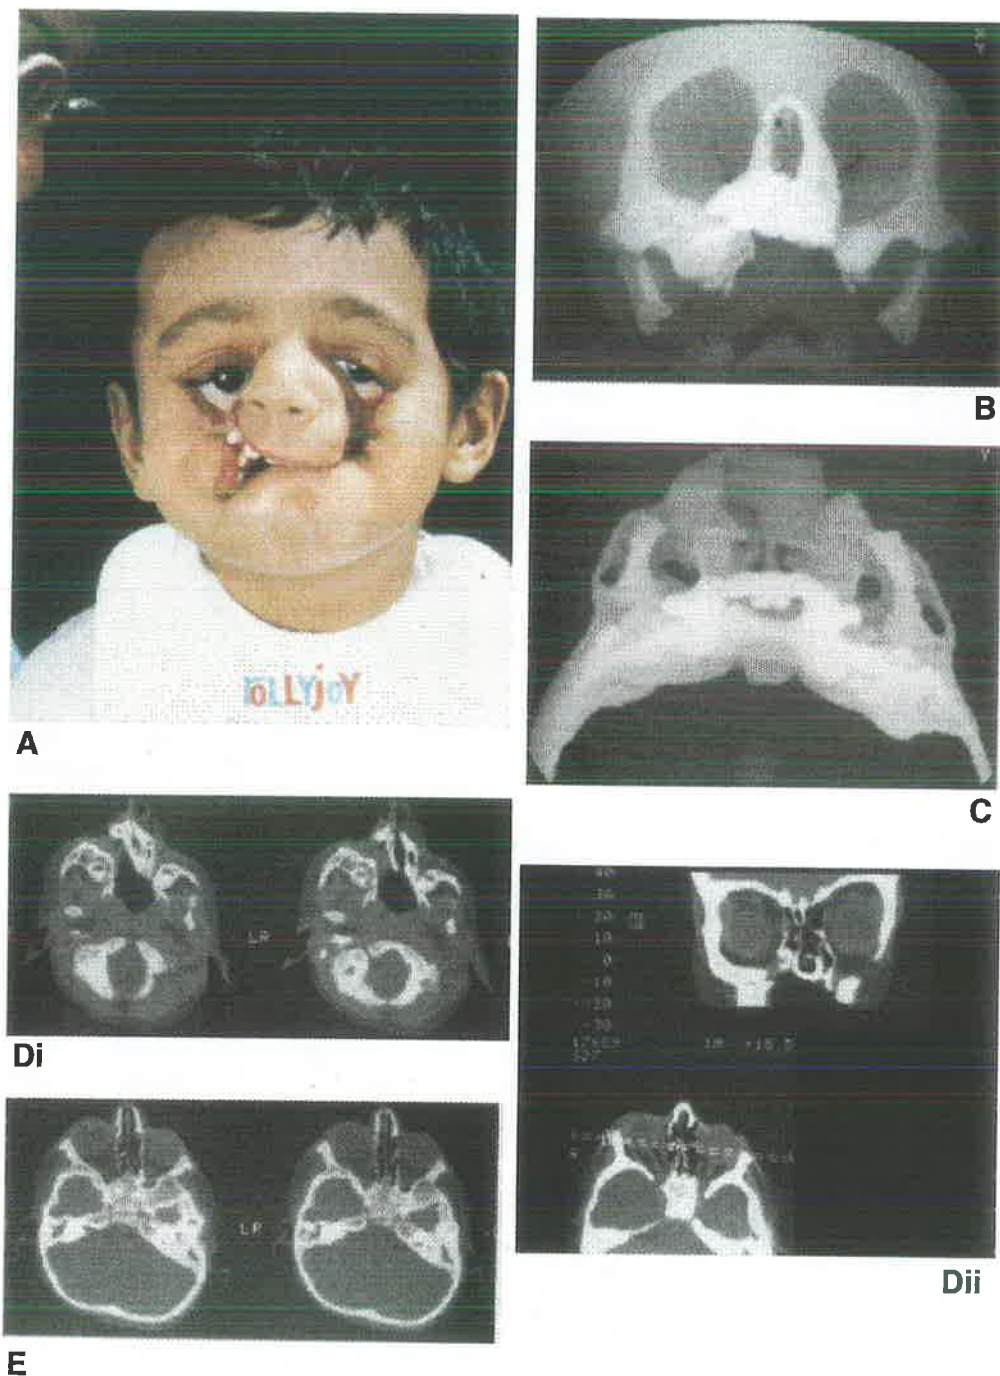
A. Two-year-old Malaysian boy of Indian descent with unrepaired clefts of the Tessier Number 4 type on the right and Number 5 cleft on the left. B. three-dimensional CT reconstruction exposes the asymmetric midfacial skeletal clefting. C. Three-dimensional CT reconstruction is tilted to view the pterygoid plates and posterior maxilla from behind. The marked cleft-induced asymmetry extends from the anterior maxilla (upper border) to the pterygoid plates and cranial base (lower border). D. Axial two-dimensional CT scan outlines the course and relation of the cleft through the lower midface (i). Coronal two-dimensional CT reformat emphasises the cleft extension into the medial portion of the orbit on the right Tessier Number 4 (ii). E. Axial two-dimensional CT scan at the midorbit level confirms the asymmetry extending from the orbits anteriorly through the base of the skull and sphenoid body to the occiput posteriorly.
